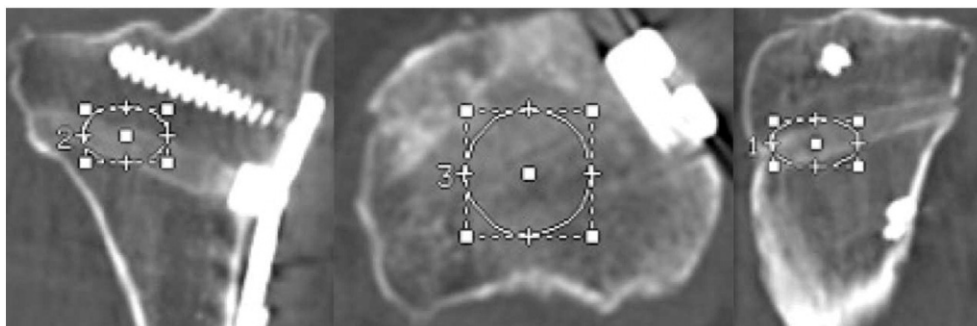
CT scan showing the three different standard planes of orientation (oblique axial, sagittal oblique and coronal oblique) to select a standard ROI (one, two, three dots resemble the measurement spots).
